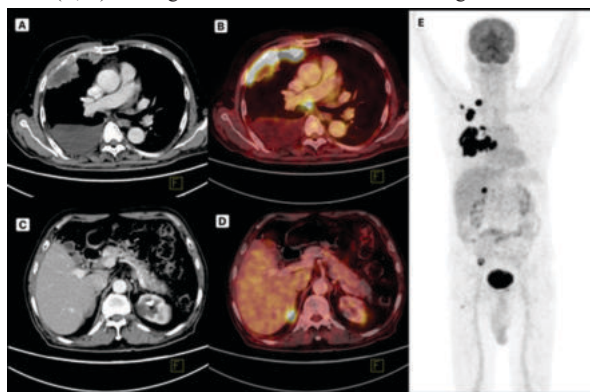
82-year-old man with EGFR- wild type stage IV lung Adenocarcinoma. CT and PET images show a 6.0 x 3.4 cm lesion in right middle lobe (A, B) with high pSUVmax = 21. Patient also has metastasis in right adrenal (C, D) and in right ilium visible in MIP image (E).
